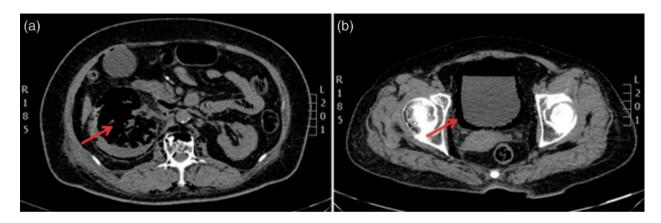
CT scan (emphysematous pyelonephritis) (images showing gas in the right kidney (red arrows) (a) and in the urinary bladder wall (red arrows) (b) (case report [11]).
